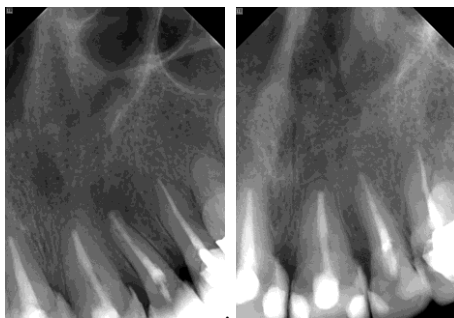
a) Maxillary left lateral tooth with previous RCT and remaining periapical lesion, b) 12-month radiographic recall showing healing of the lesion.
